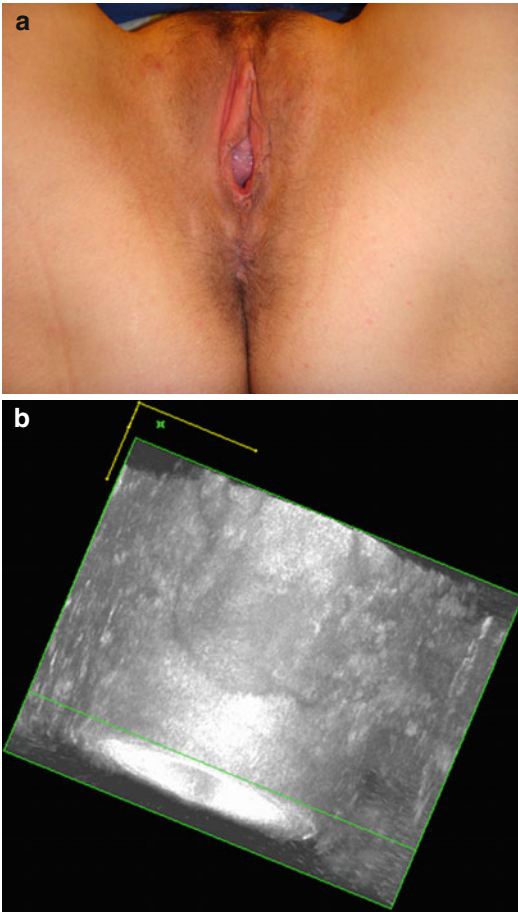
(a) Damage of the left puborectalis with deviation of the anus on the healthy side. (b) Damage of the left puborectalis on sonography
